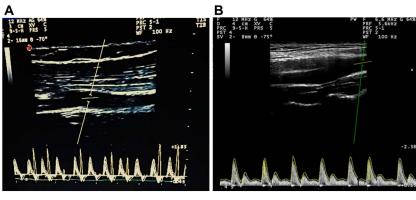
Ultrasound and Doppler images of the brachial artery (A) and carotid artery (B) during exercise.
